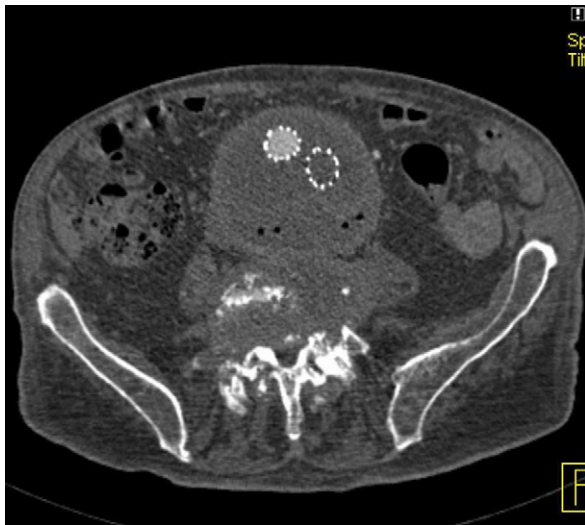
Axial computed tomography (CT) image demonstrating air within the aneurysm sac and vertebral osteomyelitis.
